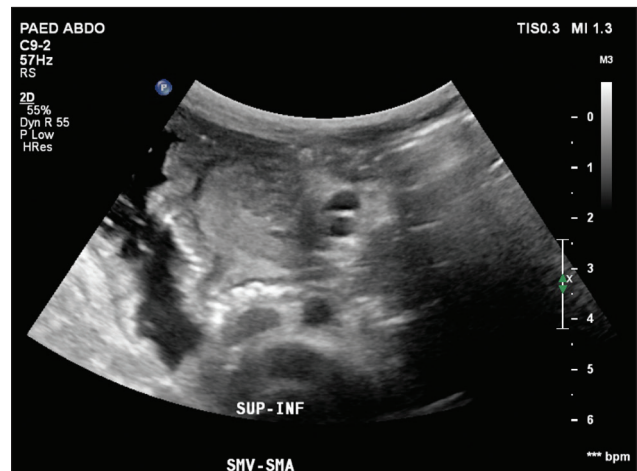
A transverse sonogram of the epigastric region across the patient's midline
